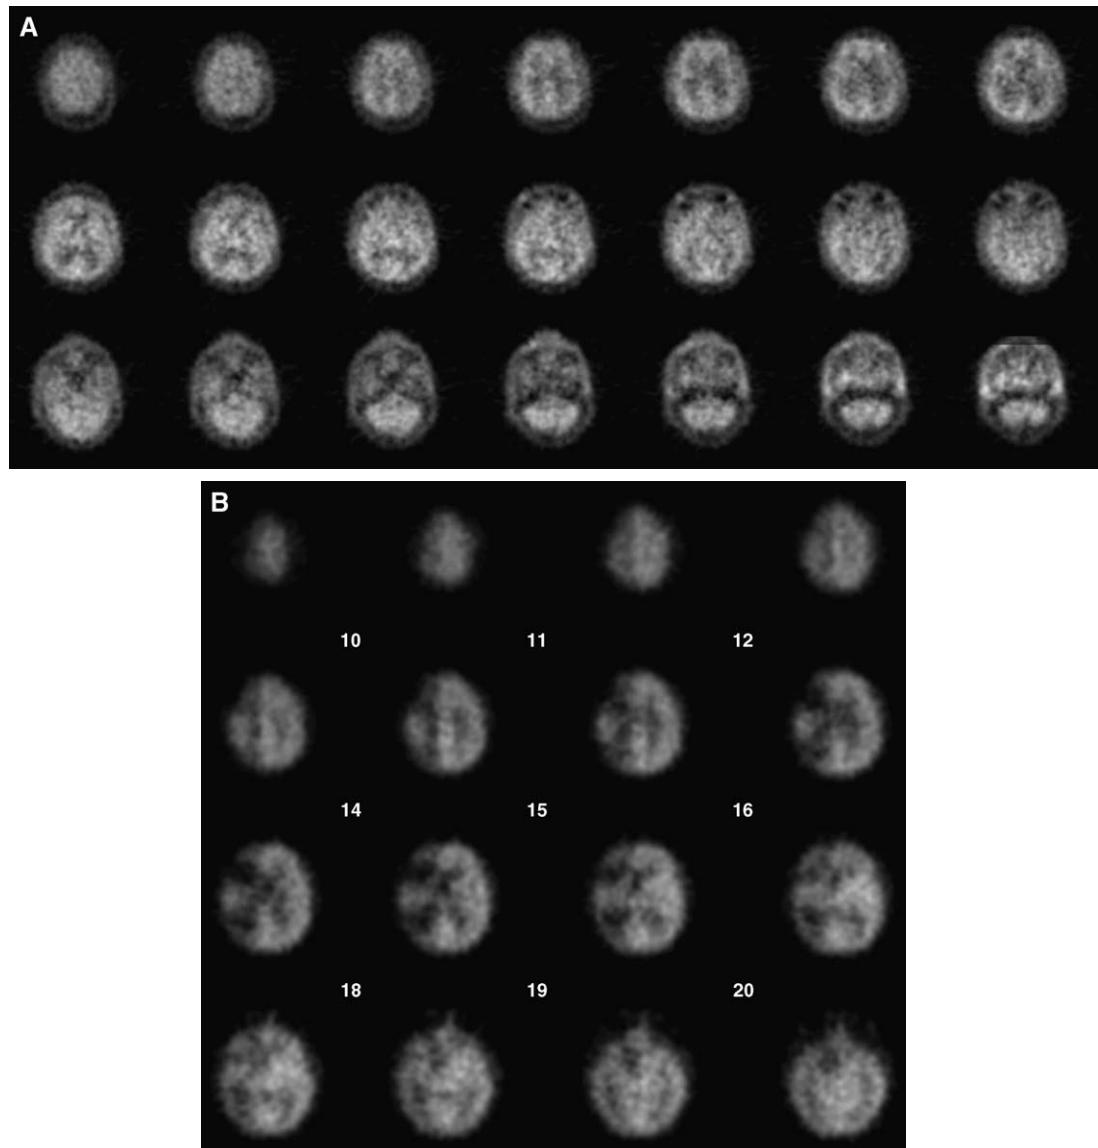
Temporary carotid balloon occlusion test (BTO) is performed with a contrast-filled non-detachable balloon catheter. Tc99m HM-PAO is injected during temporary occlusion. (A) SPECT following carotid BTO demonstrates no differential cerebral hemisphere hypoperfusion. (B) SPECT demonstrates marked hypoperfusion in a patient with massive carotid bleeding following urgent endovascular occlusion.
